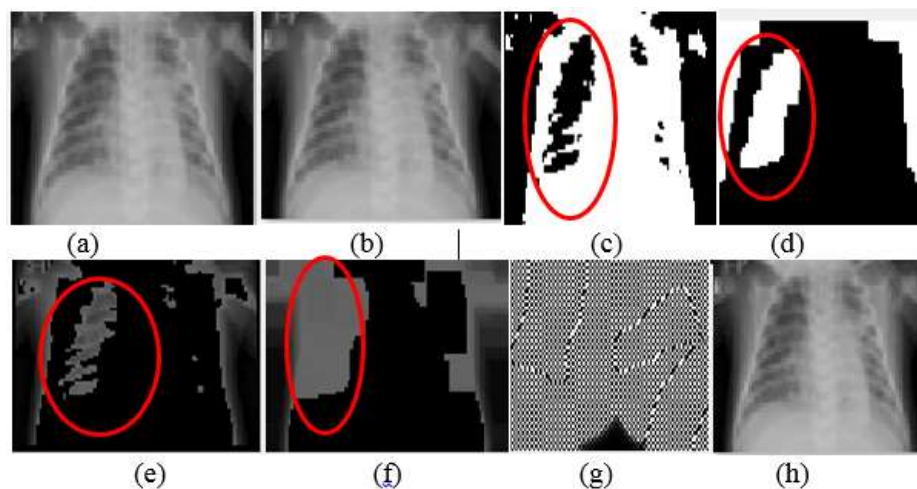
(a) - (h) Spread infect the entire part of the lung before 9 days - Chest X-Ray, image parameter extracted through mucus fluid.
